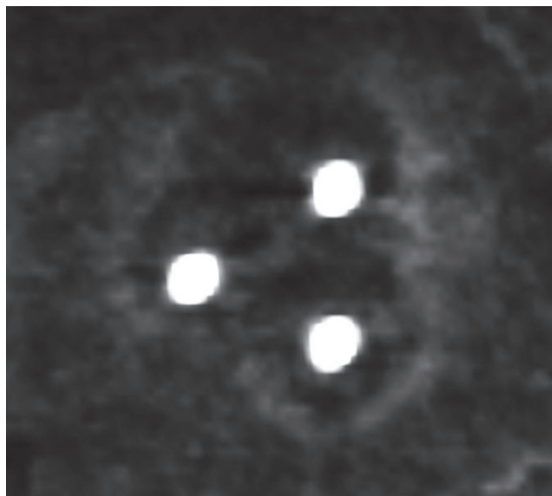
Immediate post-ablation perfusion CT shows the benign periablational enhancement surrounding the hypodense ablation zone.
